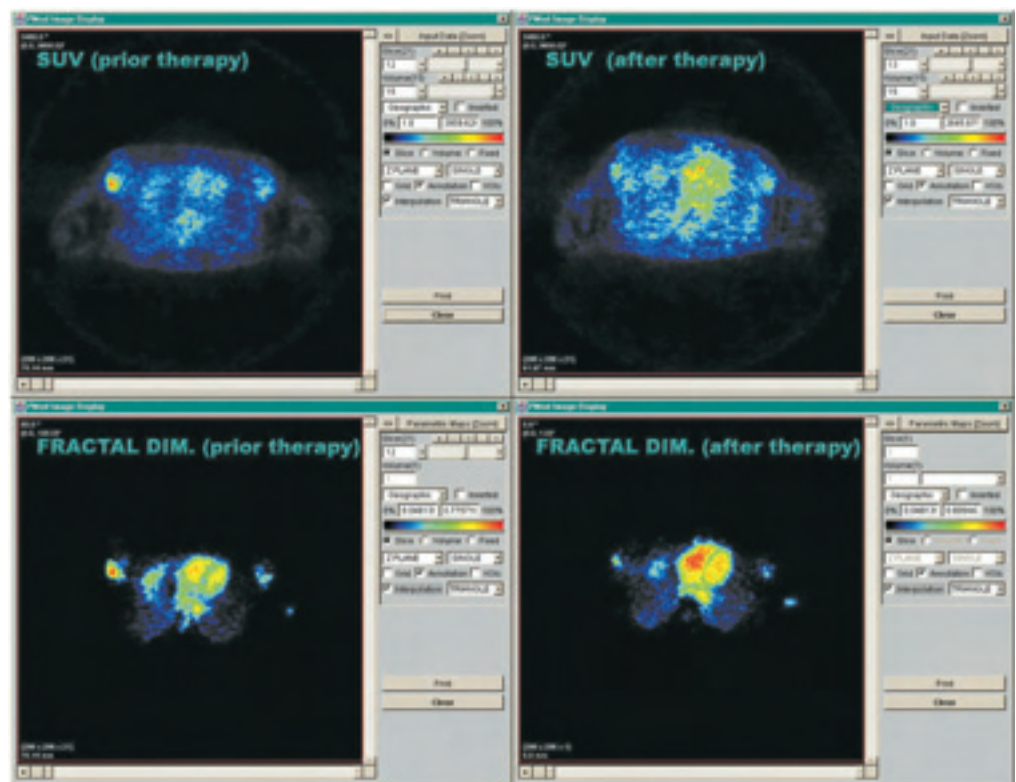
Parametric ^{18}F -FDG images based on the calculation of the fractal dimension in a patient with breast carcinomas on both sides prior and after one chemotherapeutic cycle. The delineation of the breast carcinomas is superior on the parametric images (lower row) in comparison to the SUV images (upper row)
